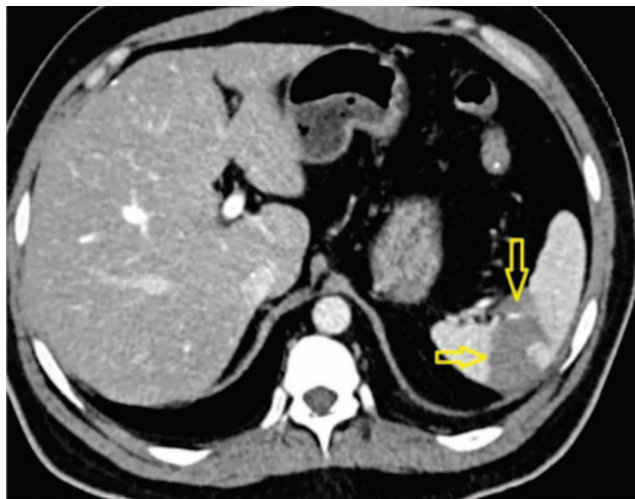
Abdominal CT. Arrows indicate the hypodense area.
